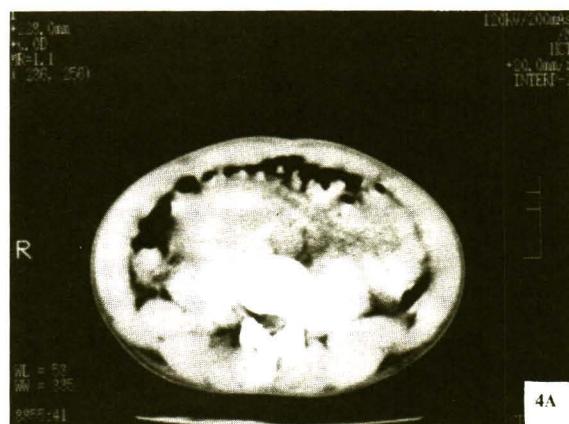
Non-enhanced CT scan demonstrates an inhomogeneous, high-attenuation mass associated with obstructive changes.
